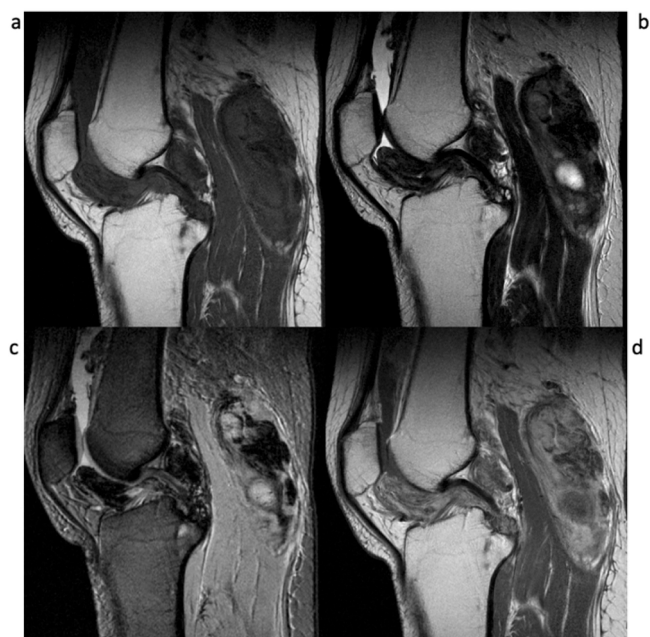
Intra-articular diffuse-type Tenosynovial Giant Cell Tumour (*D*-TGCT): MR imaging findings. Sagittal (a) T1-weighted Turbo Spin Echo (TSE), (b) T2-weighted TSE, (c) T2*-weighted GRE, and (d) post-contrast T1-weighted TSE images of the knee show multifocal villonodular mass involving the anterior and posterior compartments of the joint as well as the semimembranosus bursa. Tumour tissue exhibits low signal intensity on T2-weighted image (b) massive blooming artifacts on Gradient Spin Echo (GRE) image (c) and inhomogeneous contrast enhancement (d).
